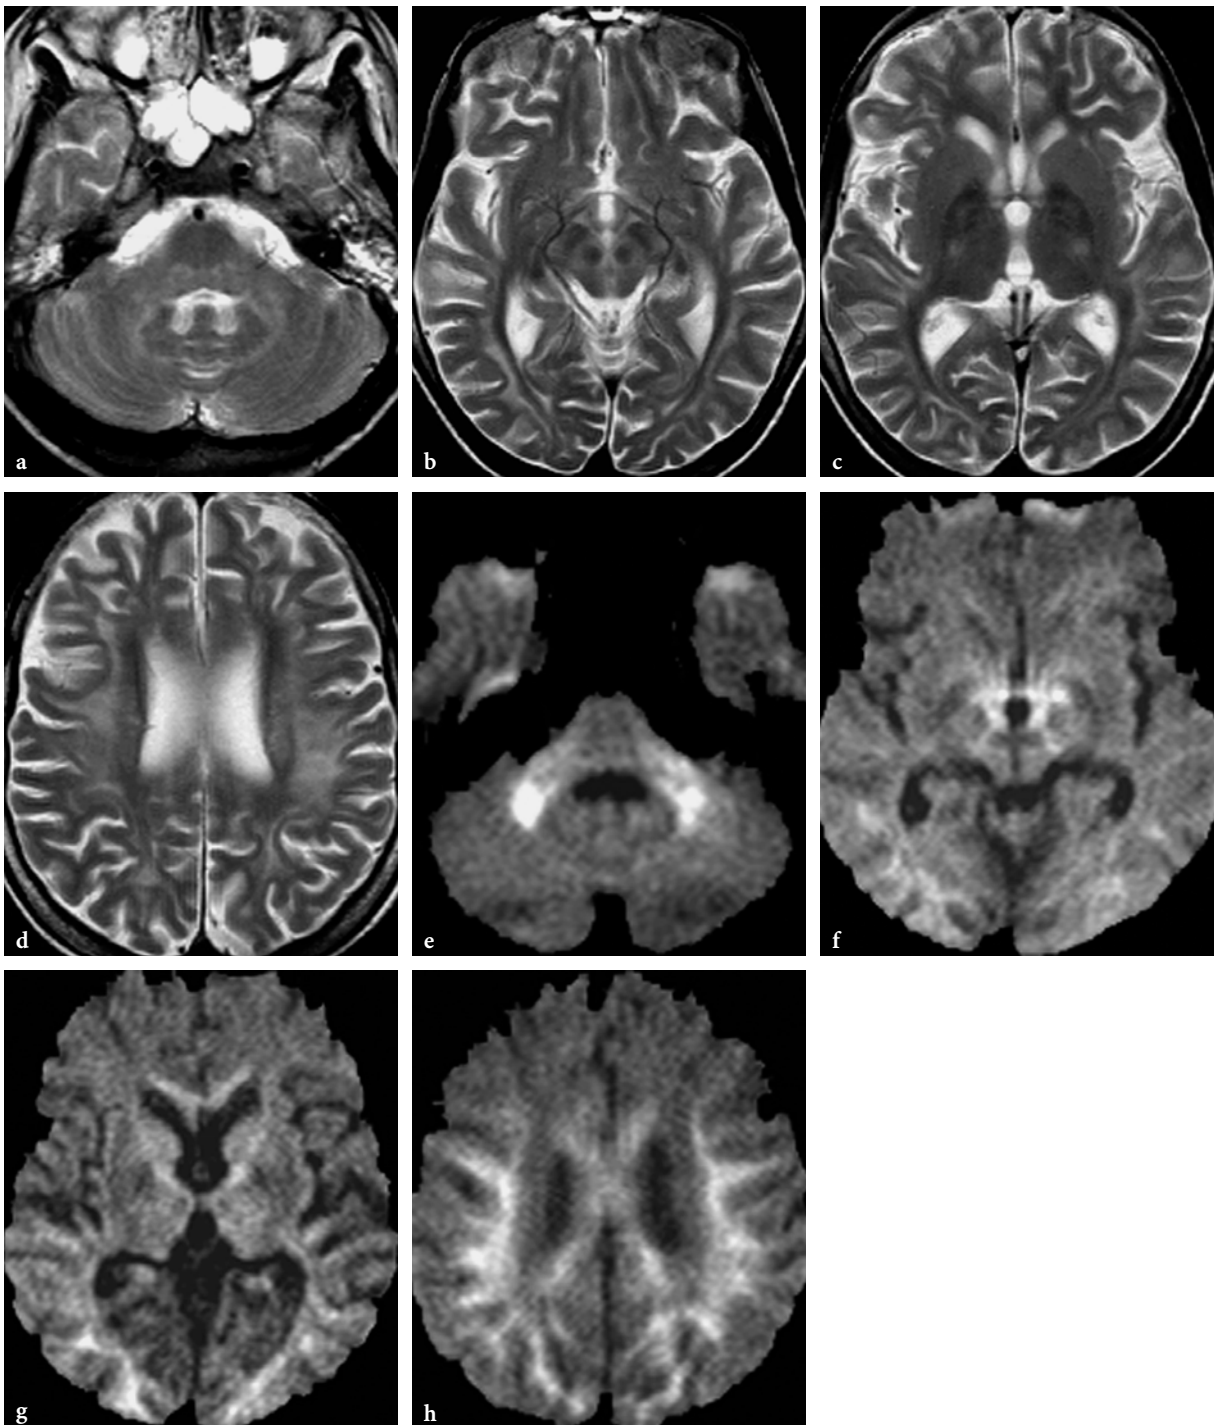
Conventional and diffusion-weighted MR imaging findings in patients with Kearns-Sayre disease. a-d Axial T2-weighted fast spin-echo images in a 15-year-old female patient. Diffuse ill-defined white matter hyperintensities are seen within the cerebral hemispheres, and less prominently within the deep cerebellar white matter and middle cerebellar peduncles. At the level of mesencephalon, a giant panda face-like pattern is suggested. The globi pallidi are hypointense, otherwise no basal ganglia or thalamic abnormality is noted. Diffuse brain atrophy. e-h Axial diffusion-weighted echo-planar images ($b = 1000s$) in a 21-year-old female patient. An essentially similar lesion pattern is seen in this patient. The abnormal areas exhibit hypersignal, consistent with isotropically restricted water diffusion, probably related to myelin edema
